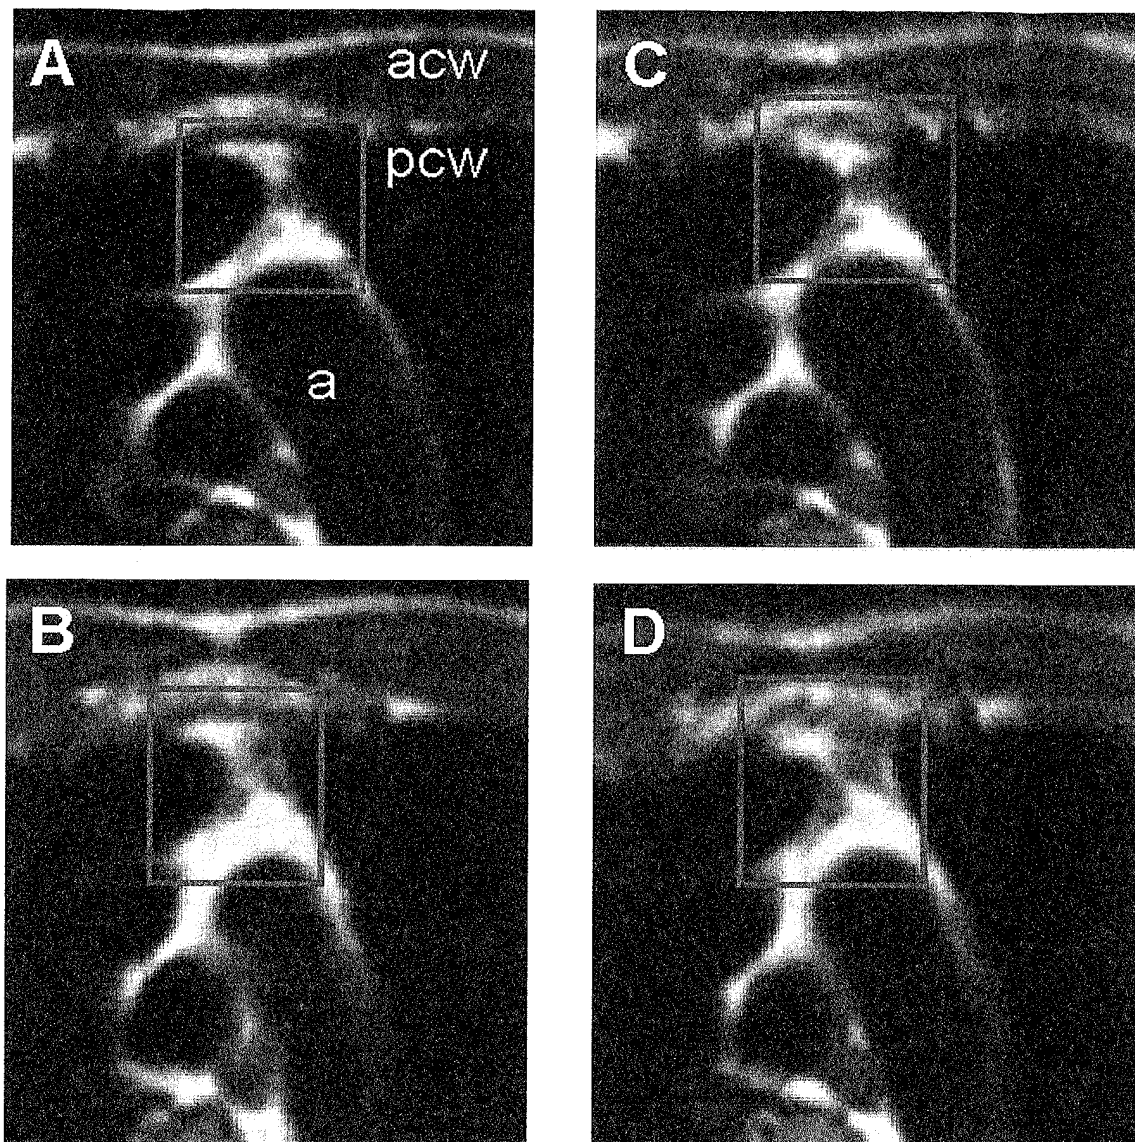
MRI scans of thymus (within the blue boxes) before (A,B) and after (C,D) approximately one month of HGH + DHEA therapy. acw = anterior chest wall; pcw = posterior chest wall; a = aorta.
